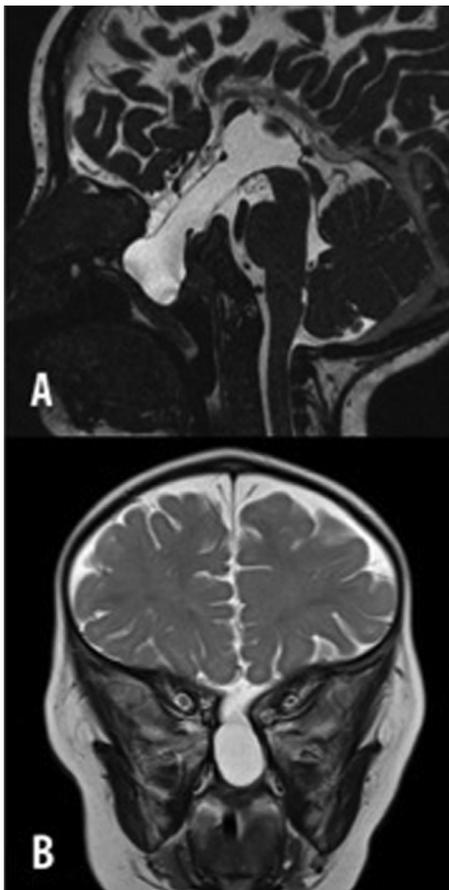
Coronal and sagittal views of T2 MRI showing large midline transsphenoidal encephalocele with herniation into the nasopharynx. MRI, magnetic resonance imaging.
